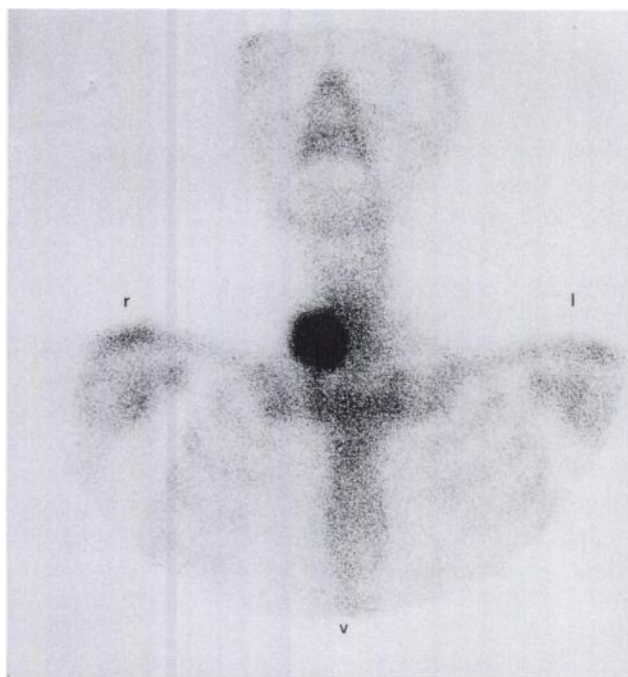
Bone scintigraphy with ^{99m}Tc -DPD. There is intense uptake of radiotracer in the mass.
